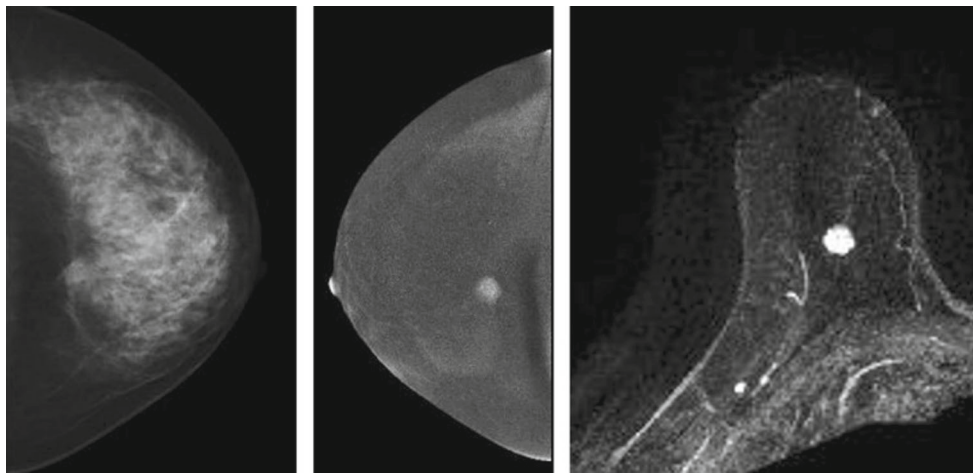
Lesion visibility in dense breast: (left) classical mammography; (center) CEM; (right) contrast-enhanced MRI
